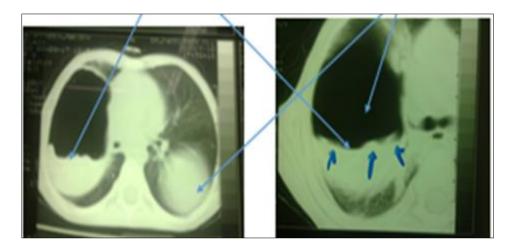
CT-scan of a patient with water lily sign but not of this patient
